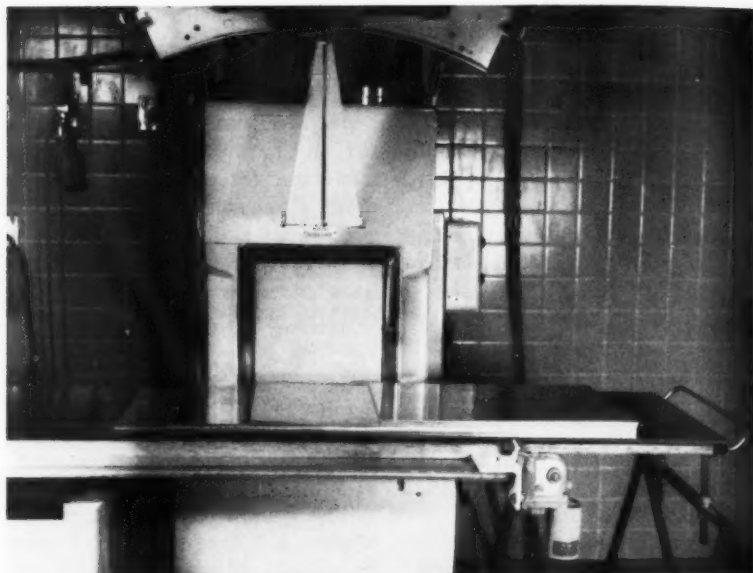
The equipment utilized to transport the patient over the film exposure area of a serialographic unit. A motor-driven table-top mounted on a platform suspended between the radiographic table and a metal stand bridges the horizontal roll film changer.
